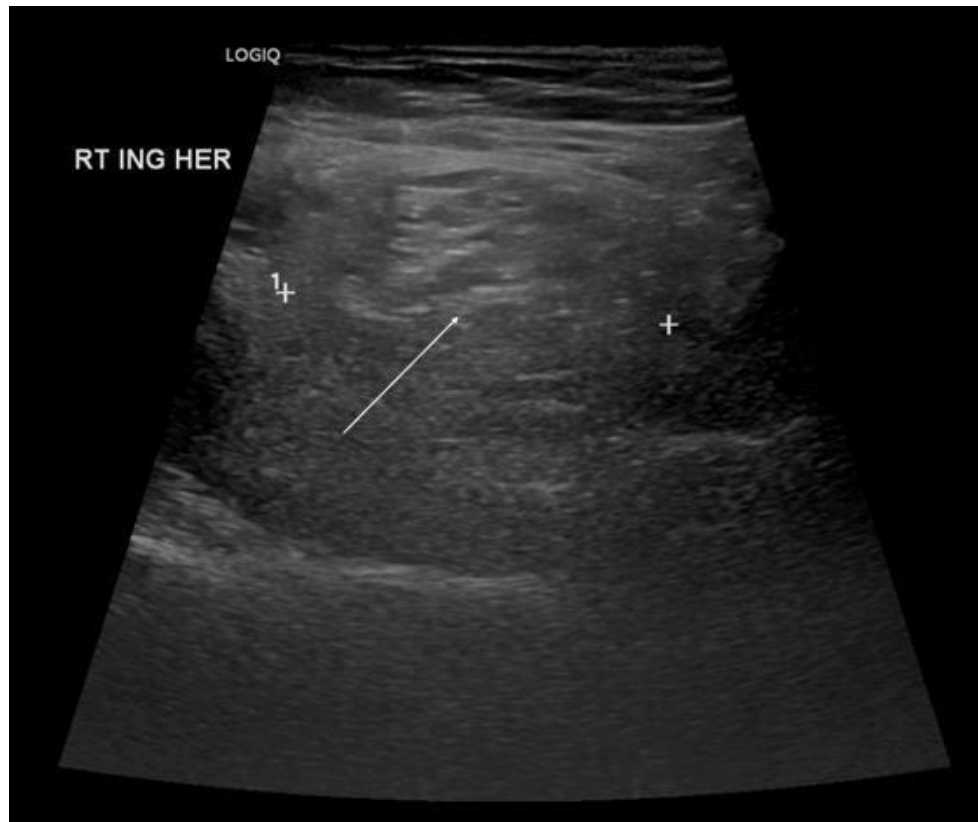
Abdominal ultrasonography revealed a large defect in the right inguinal region with a hyperechoic omentum.
